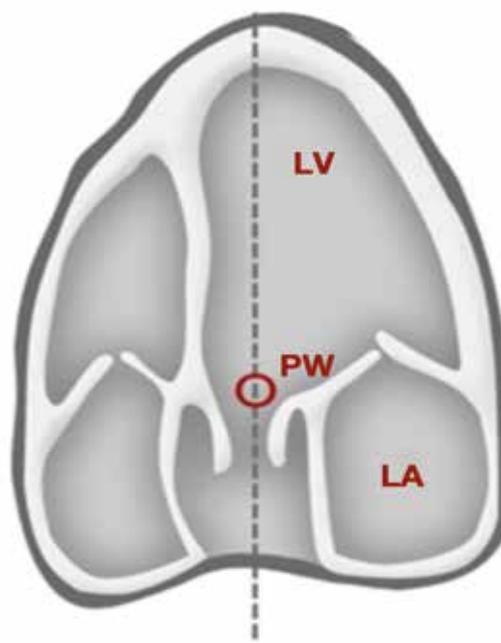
An apical five-chamber view is shown. Placement of pulse-wave Doppler (PW) in the LVOT is indicated. LA = left atrium, LV = left ventricle
